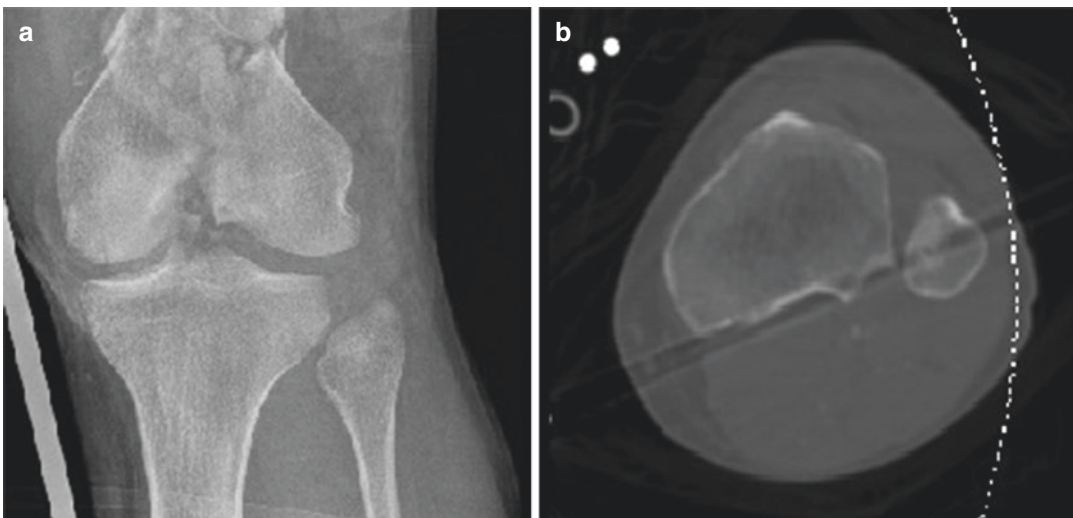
(a) Anteroposterior radiograph demonstrating comminuted distal femur fracture and proximal tibiofibular dislocation; (b) Axial Computed Tomography scan confirming a Type II Anterolateral dislocation of the fibula
